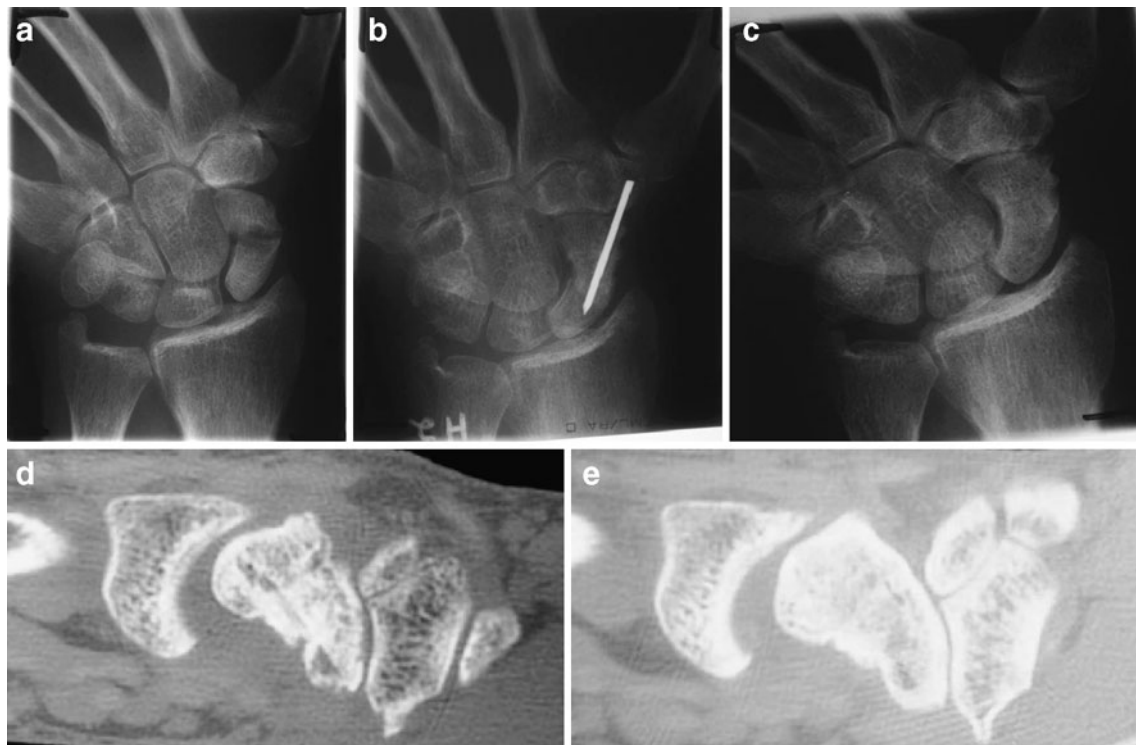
Forty-six year old male. a Preoperative radiographs demonstrating nonunion of scaphoid waist. b Evidence of union of iliac crest bone graft at 3 months post-operative. Contour of scaphoid showing obvious distortion with *marked narrowing* of scaphoid waist
